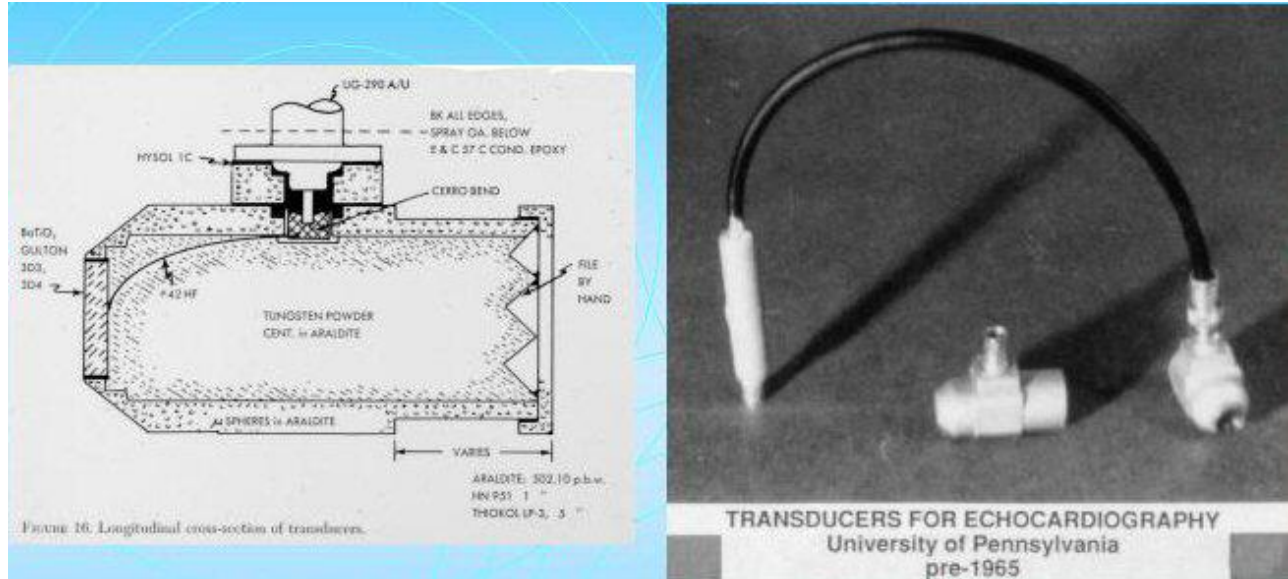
Transducers for Echocardiography.
